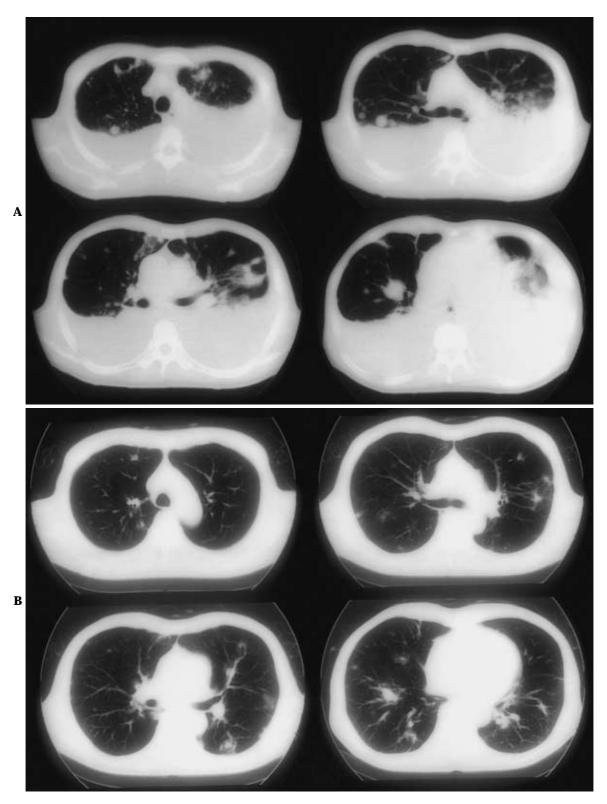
A. Chest computed tomography on admission, showing bilateral nodules and pleural effusion. B. Chest computed tomography scan 1 month after chemotherapy, showing a decrease in nodules and effusion.
